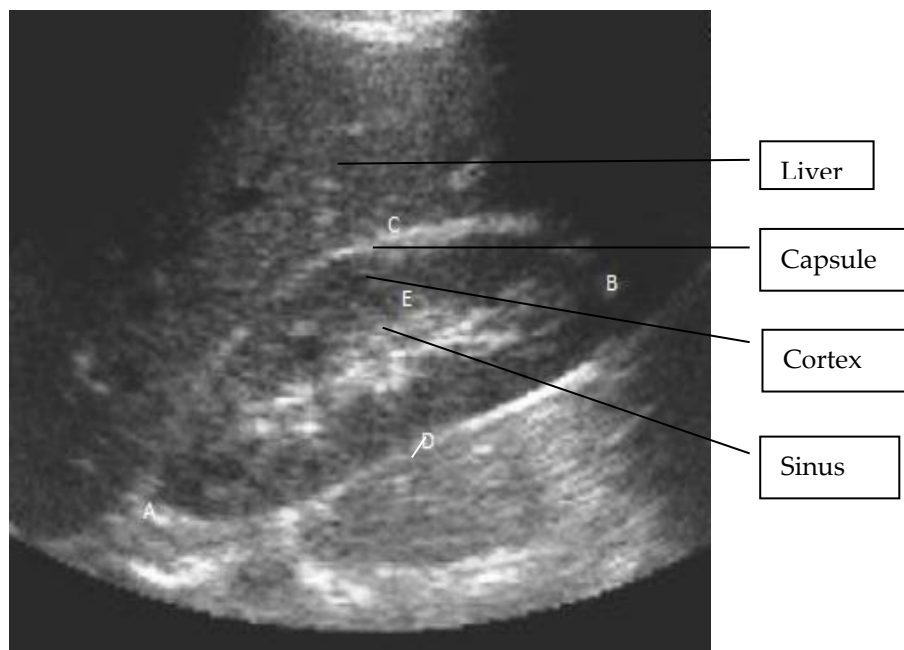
Longitudinal ultrasound image of the right kidney
